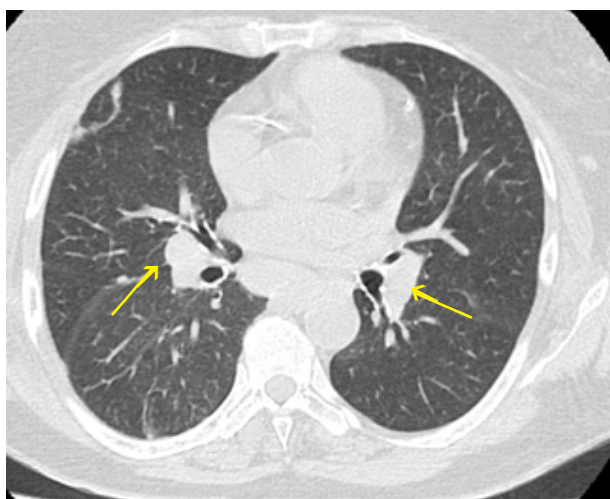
HRCT of the chest showing bilateral mediastinal lymphadenopathy.
